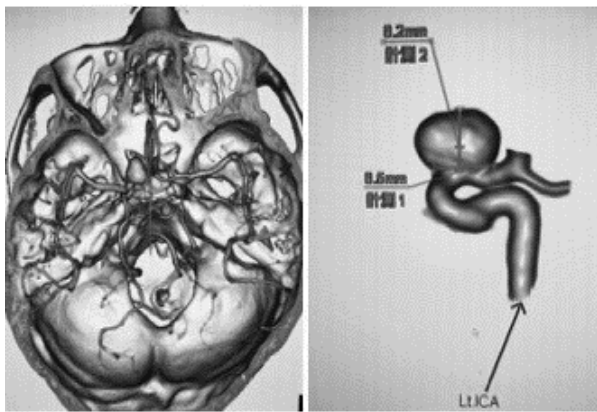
3D-CTA Show left Paraclinoid aneurysm with fundus height 8.2 mm, neck width 8.5 mm
